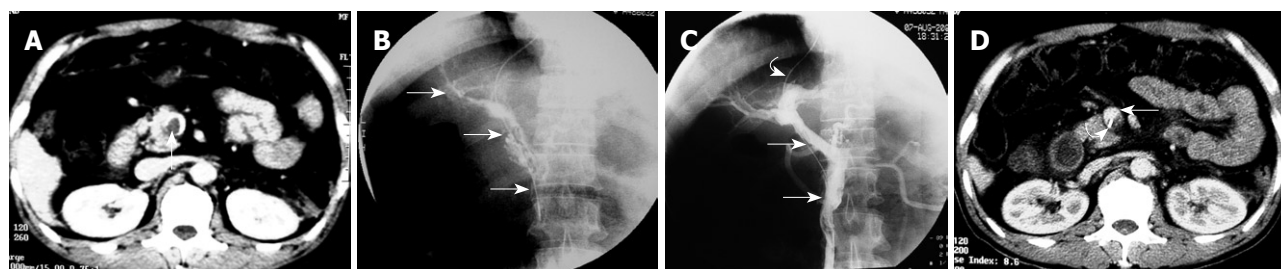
Case 2: A 43-year-old man with epigastric pain, diarrhea, fever, and vomiting for 1 wk. He had undergone splenectomy 3 wk previously. A: Selected axial image from admission contrast-enhanced CT, on postoperative day 21, shows thrombus (arrow) within the SMV; B: Pre-treatment direct venography via transjugular approach access to the portal vein shows extensive thrombosis of the SMV extending into the main PV and intrahepatic branches (arrows); C: Follow-up direct portal venography via the infusion catheter (curved arrow), obtained 6 d after the catheter infusion of thrombolytics, shows patent PV and SMV with only minimal residual wall thrombus (arrows); D: CT image at the same level as in Figure 2A obtained 6 d after the catheter infusion of thrombolytics, before the infusion catheter removal, shows the wide patent SMV (arrow) with only minimal residual wall thrombus. Note the infusion catheter within the SMV (curved arrow).
